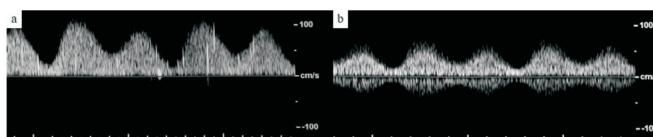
(a) Proximal artificial cerebral blood flow dopplergrams in haemorrhage; (b) distal artificial cerebral blood flow dopplergrams in haemorrhage.
